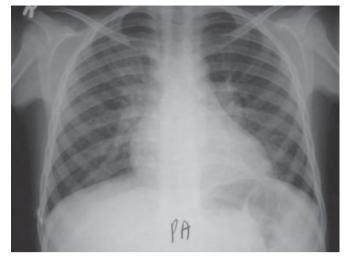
Chest radiograph (A) and chest CT scan (B) of a child with miliary tuberculosis showing multiple diffuse small nodules.
